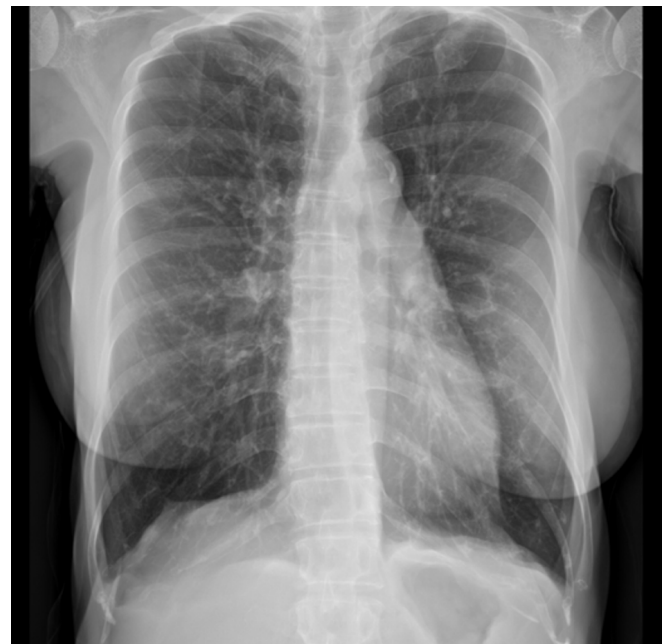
Chest radiography taken at the emergency department visit shows hyperinflated lungs with flattened hemidiaphragms and mild emphysema in the lung fields.
